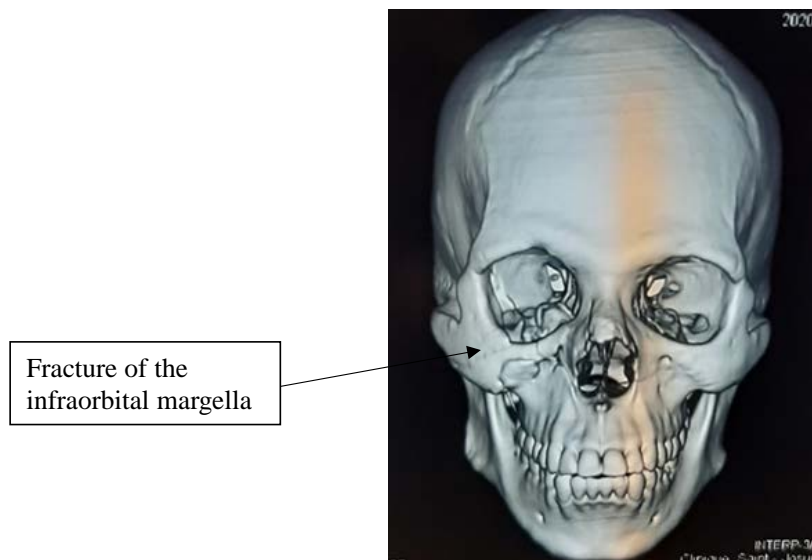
Three-dimensional reconstruction CT scan. Fracture of the infraorbital margella of the right zygomatic bone.
